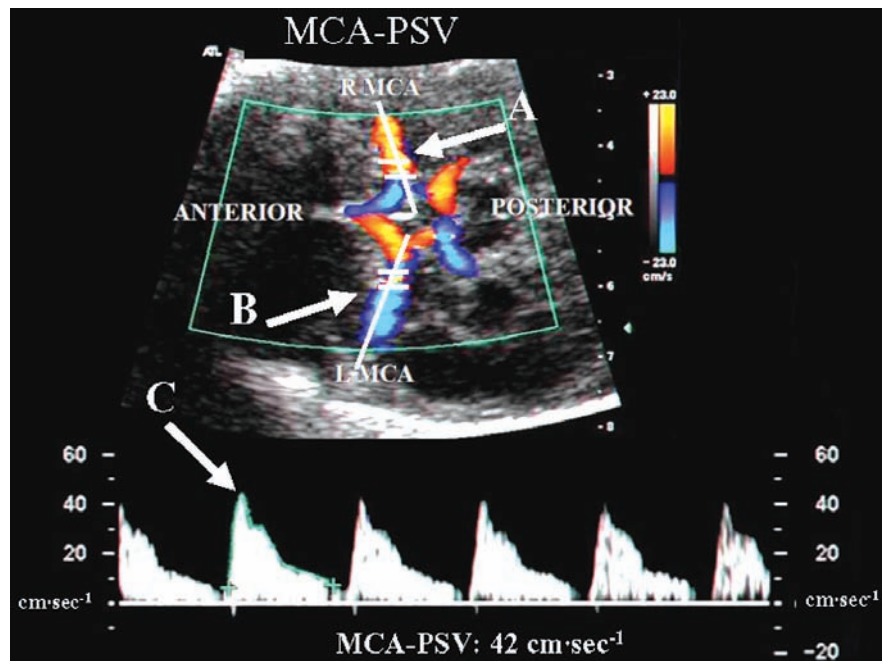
Doppler assessment of the fetal MCA. (A) Correct position of Doppler cursor over anterior MCA. (B) Correct position of Doppler cursor over posterior MCA. (C) Correct measurement of the PSV. MCA, middle cerebral artery; PSV, peak systolic velocity.
